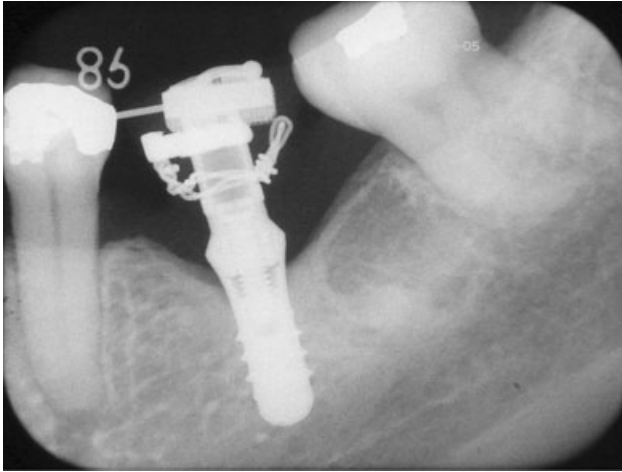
The periapical radiograph taken 3 years after the implant placement (case 8).
